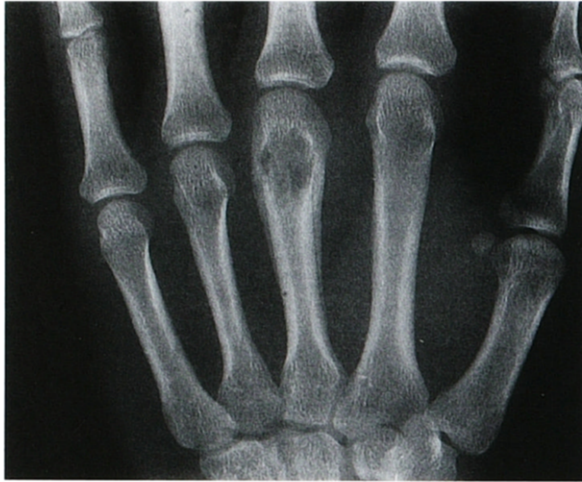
Posteroanterior radiograph of the hand showing a 1.5 cm long lytic lesion at the distal part of the middle finger metacarpal. Benign appearing laminar periosteal new bone surrounds the lesion.
